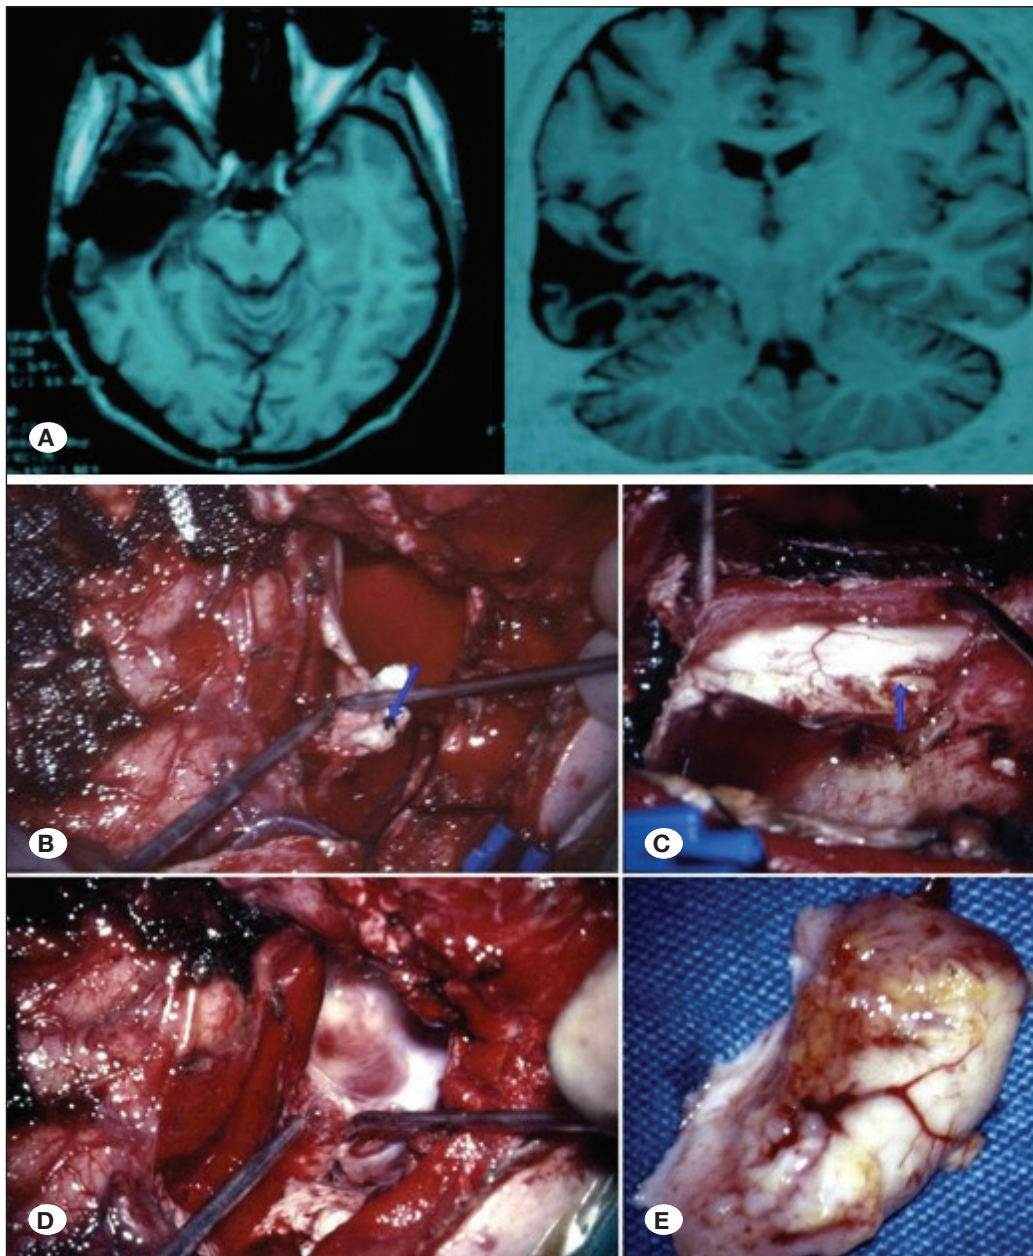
A) Preoperative brain magnetic resonance imaging (MRI) sections (left: T1W axial, right: double inversion recovery coronal) of patient #4; B-E) Intraoperative surgical view and remnant tissue (blue arrow) in mesial temporal region (B, C), surgical view of mesial temporal region after resection (D), and hippocampal remnant (E).
